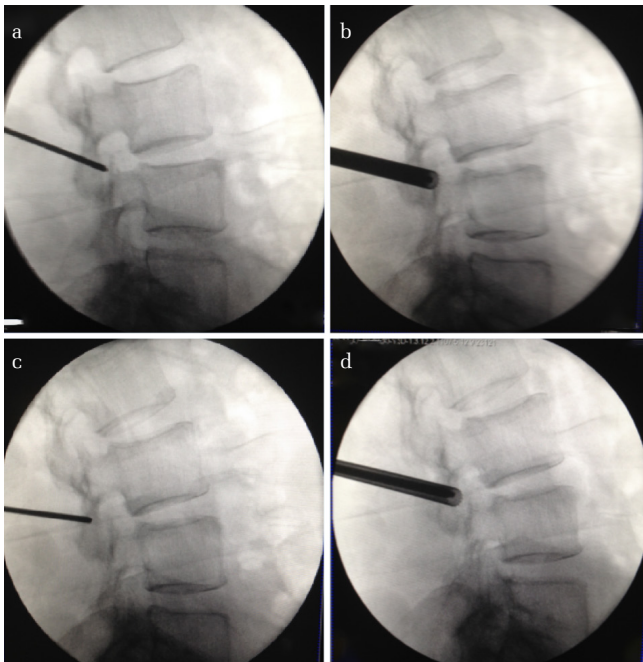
a-d. a. Lateral X-ray showing placement of a Kirschner wire during the first foraminoplasty. The tip of the Kirschner wire is fixed on the joint space of facet joints, the middle part of the SAP in the lateral fluoroscopic view. b. Lateral X-ray showing insertion of a trephine to complete first foraminoplasty. c. Lateral X-ray showing placement of a Kirschner wire during the second foraminoplasty. The tip of the Kirschner wire is shifted backward toward the inferior articular process of upper segment. d. Lateral X-ray showing insertion of a trephine in the second foraminoplasty, in order to decompress the dorsal nerve root
